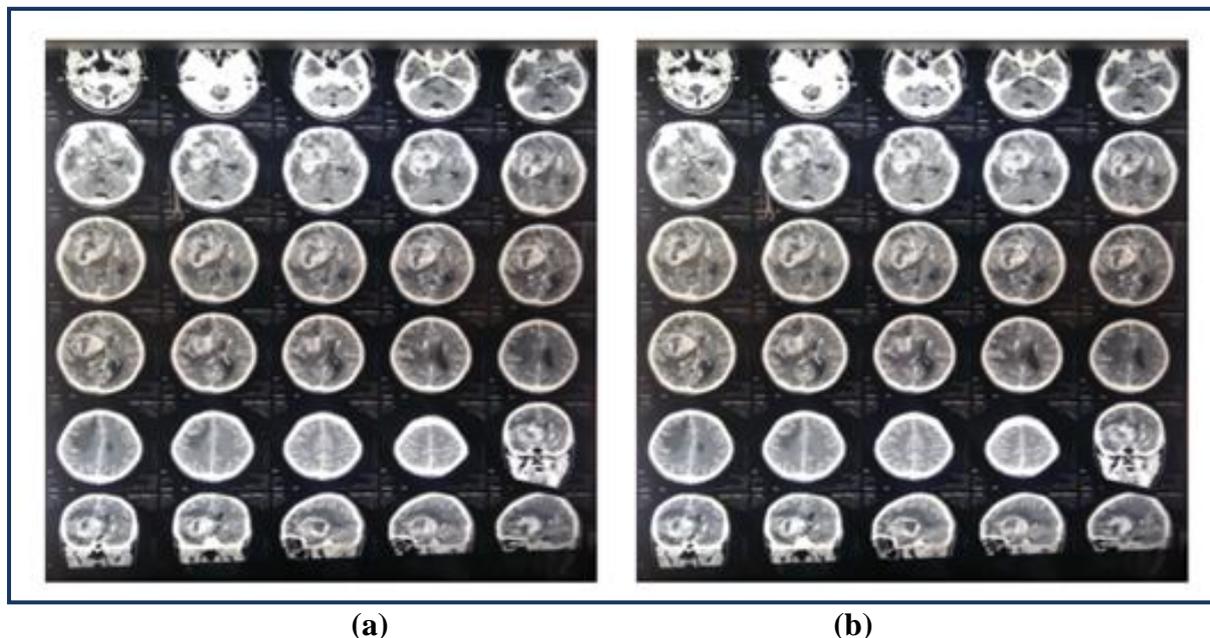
(a) CT Scan Results of The First Patient (b) CT Scan Results of The Second Patient
